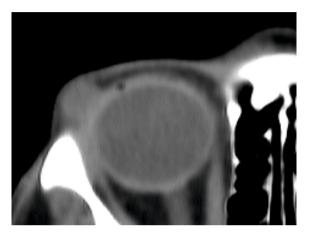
CT identifying palpebral pleomorphic adenoma
